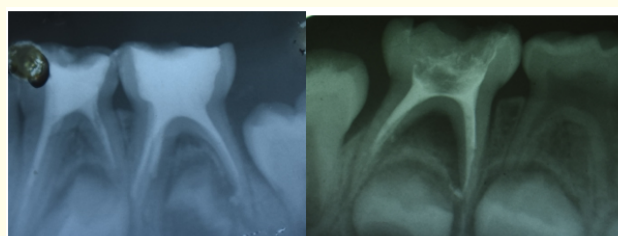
Postoperative radiograph showing pulpectomised 84,85 and 75.
